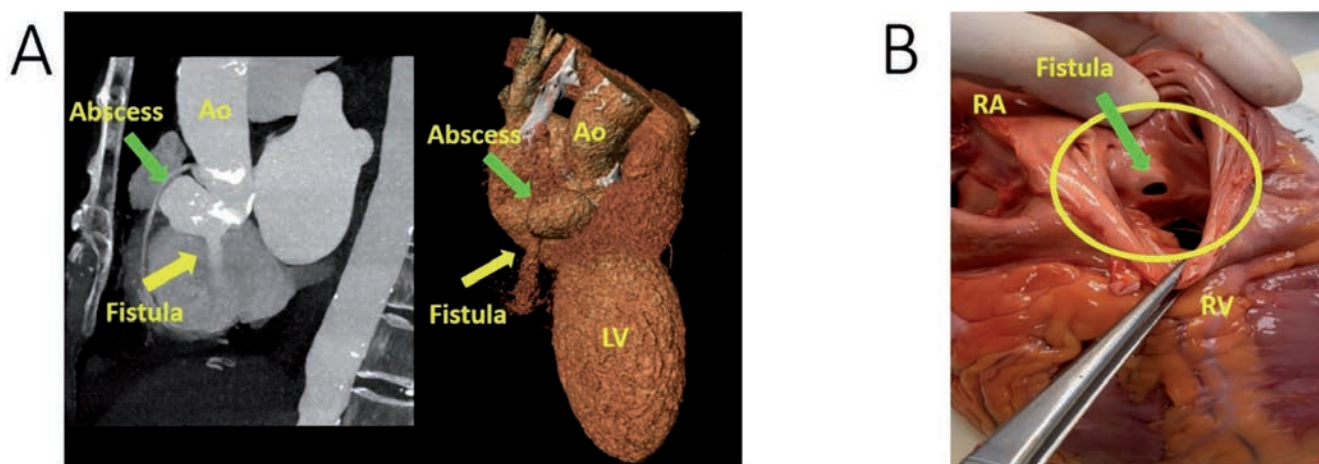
A) Coronary computed tomography: aorto-right atrium fistula. 3D reconstruction of the fistula between the pseudoaneurysm (green arrow) of the aorta and the right atrium. The yellow arrow points out the jet between the abscess and the right atrium. The right chambers were removed from the heart; B) autopsy findings: fistula from the aorta into the right atrium. Ao, aorta; LV, left ventricle; RA, right atrium; RV, right ventricle.
